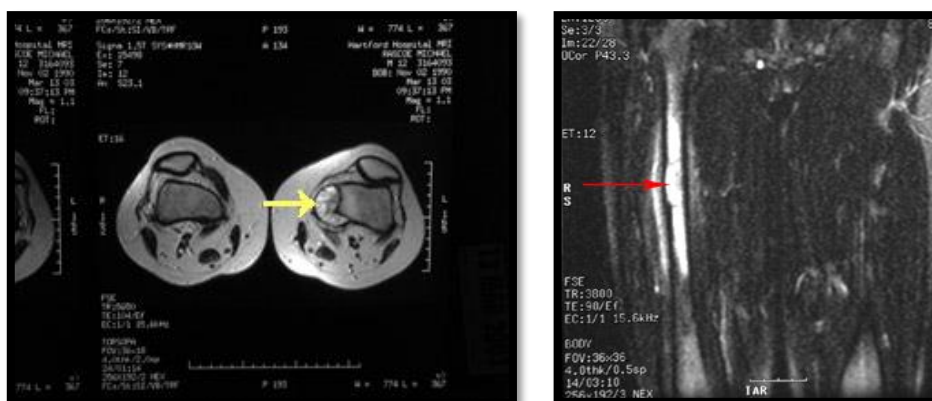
Shows the cross-sectional MRI appearance of the tumor
